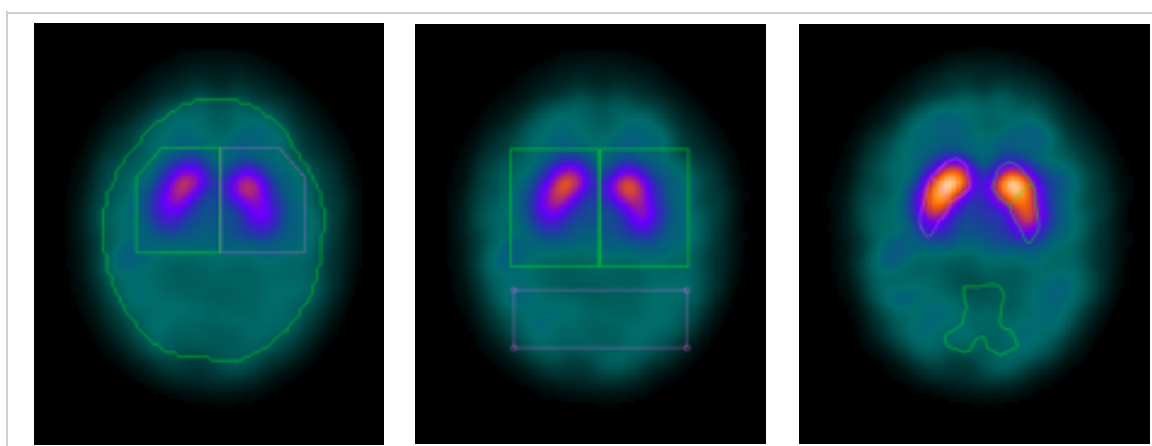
The three VOIs definition used in the QuantiSPECT software
